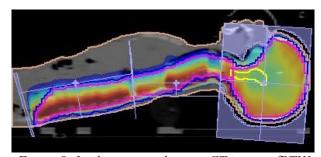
Isodose curve show on CT image of PTV1 3.1.2. Plan 2: Boost irradiation at primary tumor 18Gy/ 10Fx, VMAT technique.
